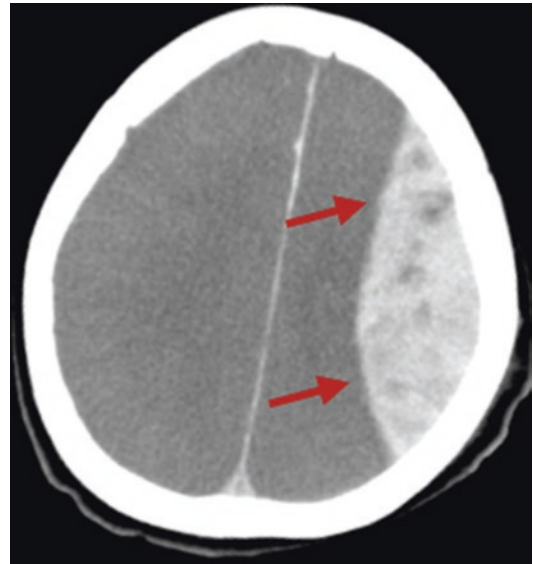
Axial brain computed tomography image of a typical acute epidural hemorrhage. A convex lentiform high-density area can be seen in the left side (arrows)
